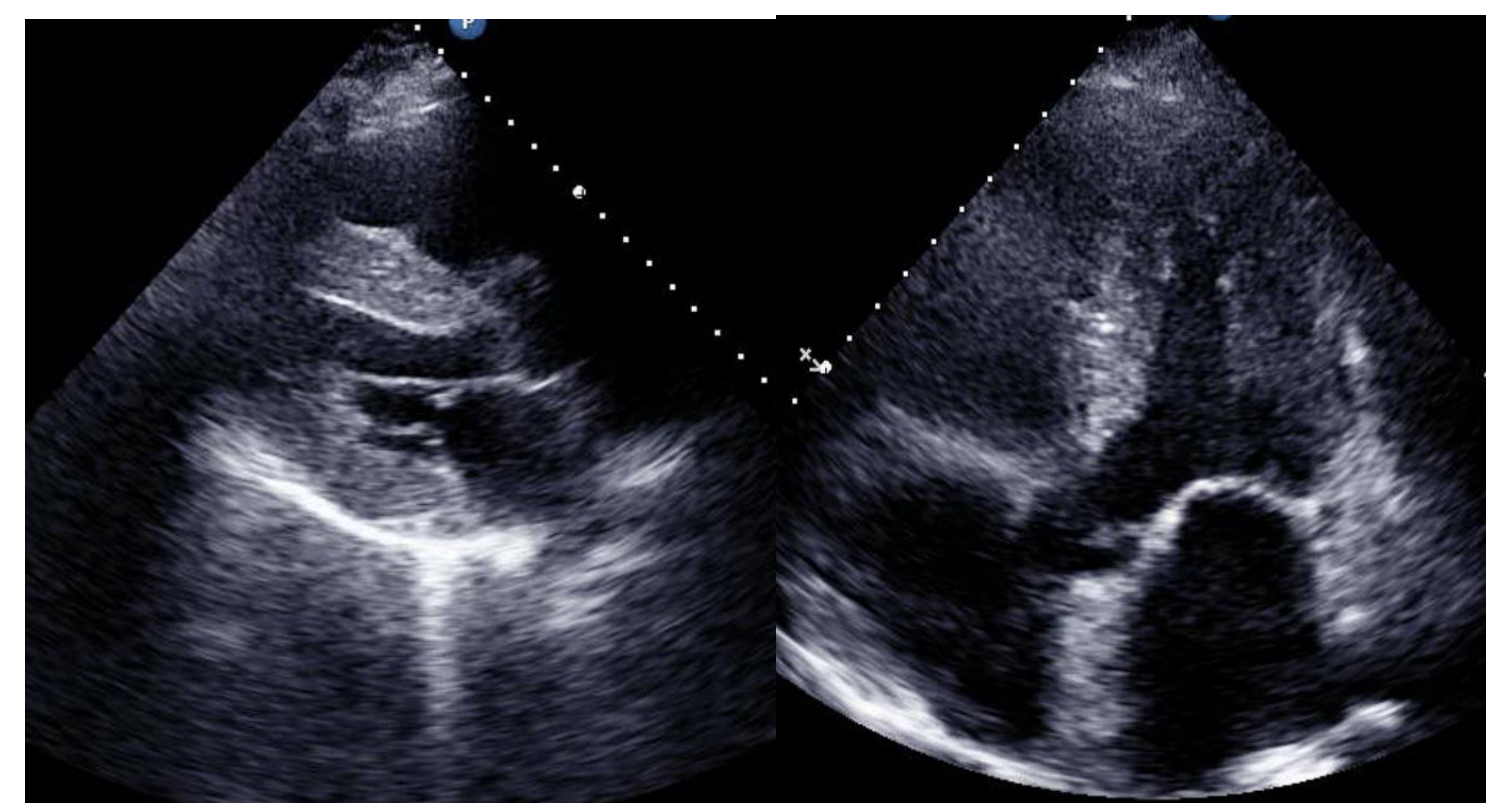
+ 1B: Echocardiogram showing concentric LVH & preserved apical function. Sparkling texture also visible in both images.
